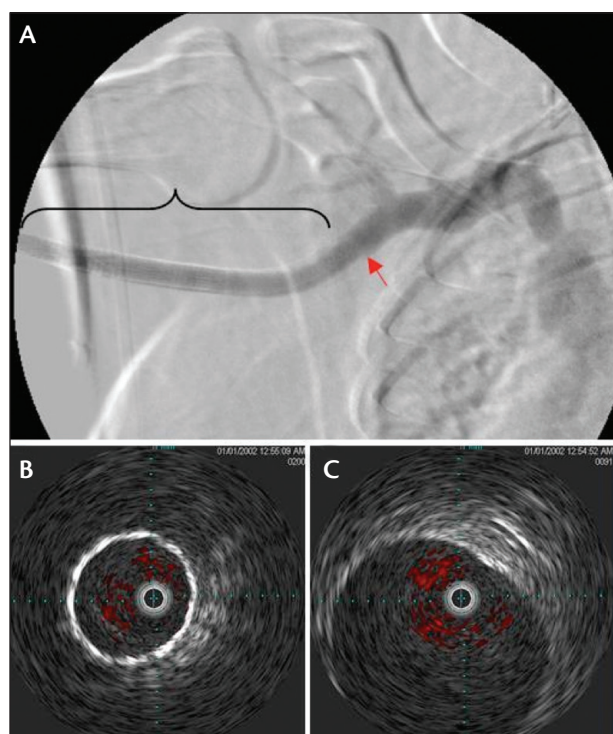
Case example of the GORE VIABAHN Device (bracket) extending an AV access graft into a larger outflow vein (arrow). The angiographic view demonstrates little-to-no backflow observed (A). Intravenous ultrasound visualizes the smaller-diameter cross-section of the GORE VIABAHN Device (B) as compared to the outflow vein (C).
